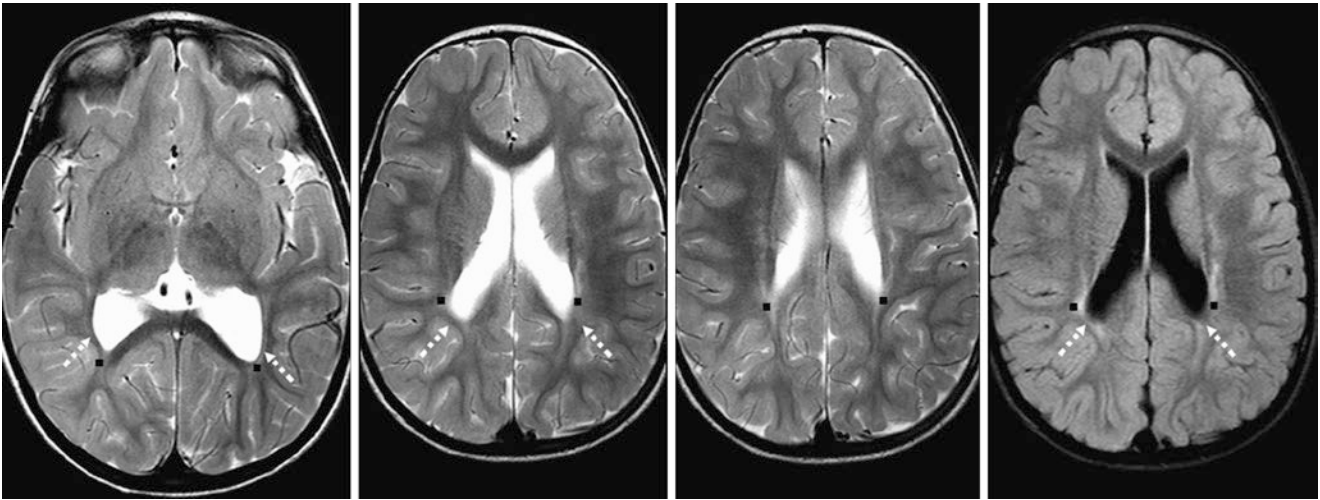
Comparison case of periventricular leukomalacia (PVL). A 3-year-old with a history of prematurity and no prior MRI underwent a 3T MRI with SE T2WI (*left three images*) and FLAIR (*right*). The
